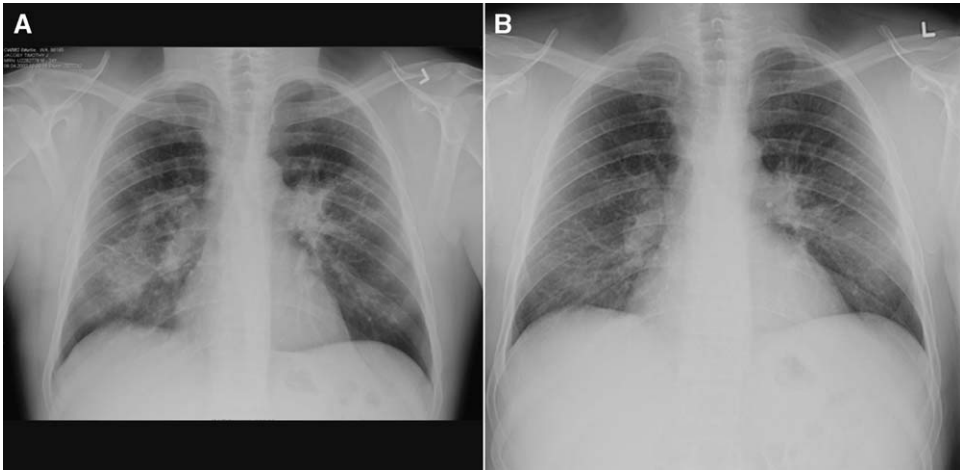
“Alveolar” sarcoidosis: Pre- (A) and posttreatment (B) chest radiographs show airspace opacities and bilateral hilar lymphadenopathy. There is significant resolution on the posttreatment radiograph.
